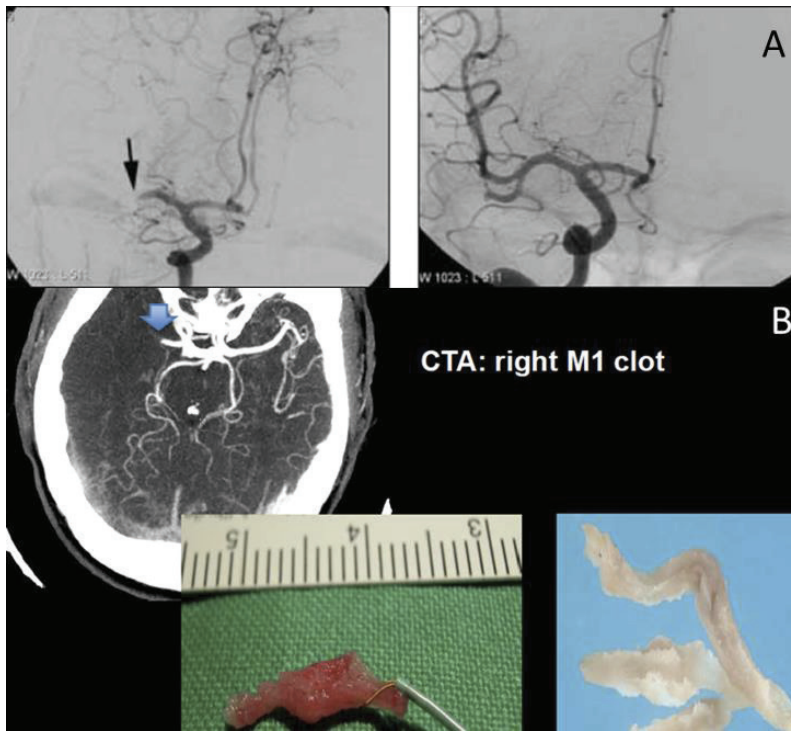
A) cerebral angiography. *Left:* Pre-treatment angiogram shows complete occlusion of proximal right middle cerebral artery (black arrow). *Right:* Post-treatment angiogram shows complete recanalization, which correlated with immediate neurological recovery. B) CTA also shows the right M1 occlusion and we can also see the retrieved clot.
